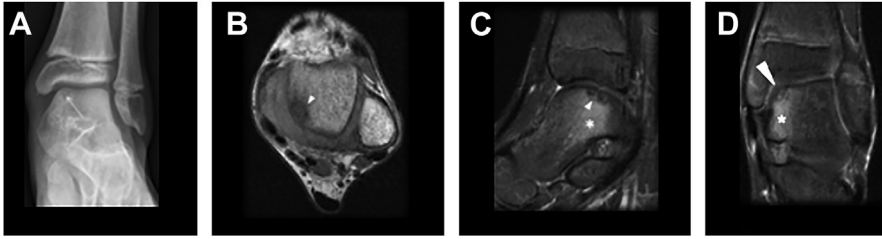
Osteochondritis dissecans. An 8-year-old boy with deep ankle pain for 2 years, which worsened after physical activities. (A) CR mortise shows mild irregularity of the bone plate at the medial segment of the talar dome (*arrow* in A). (B–D): MRI showing osteochondritis dissecans at the posterior medial shoulder of the talus, with mild impaction of the subchondral bone plate (*arrowheads*), and adjacent bone marrow edema (*asterisk*).
